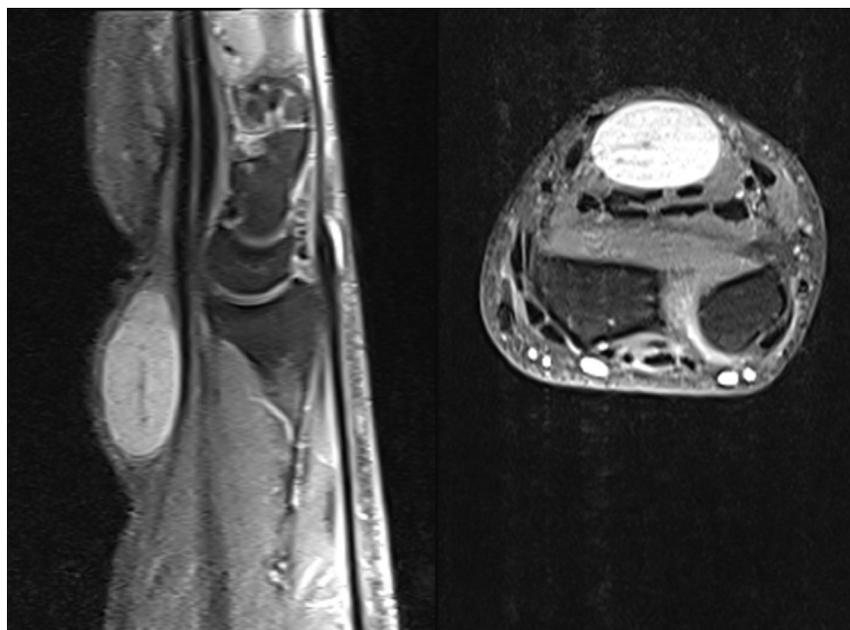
Axial and sagittal magnetic resonance images of the mass before the first surgery.
